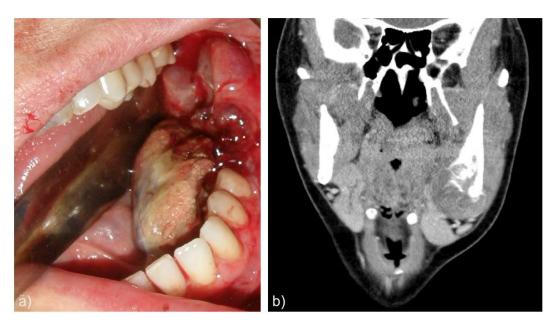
a) Intraoral clinical manifestation of tumor in the left mandibular molar area showing bleeding. b) CT coronal section image of the same lesion showing an area of osteolysis.
